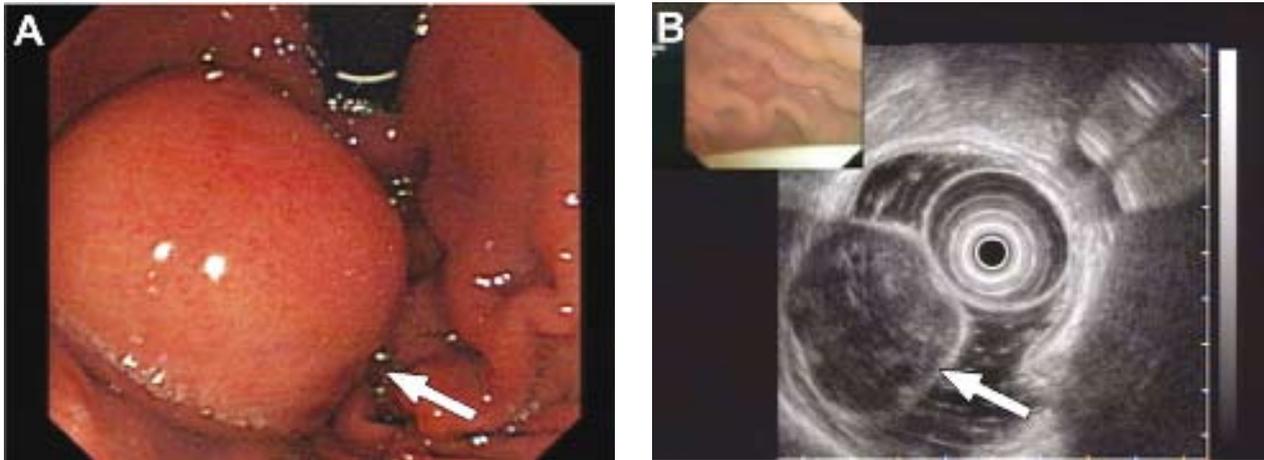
A 49-year-old man with a gastric gastrointestinal stromal tumors (GISTs) at intermediate risk a) Ultrasonic endoscope b) shows endoluminal mass in stomach, which stems from the muscular layer (arrow).
